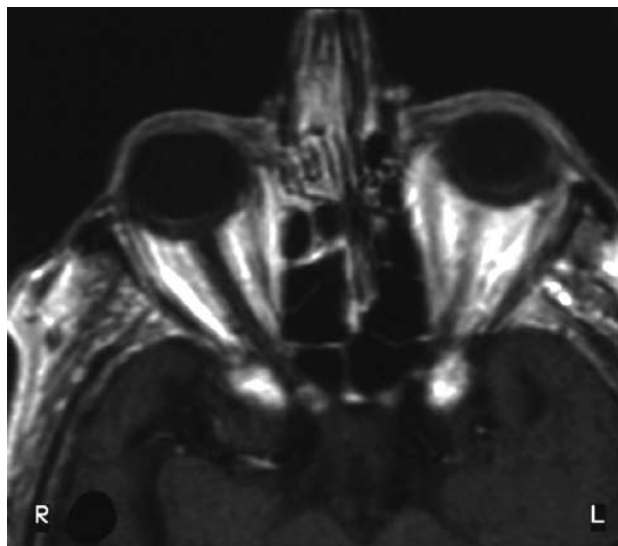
Contrast-enhanced MRI reveals left optic nerve enhancement (T1 weighted spin echo).
